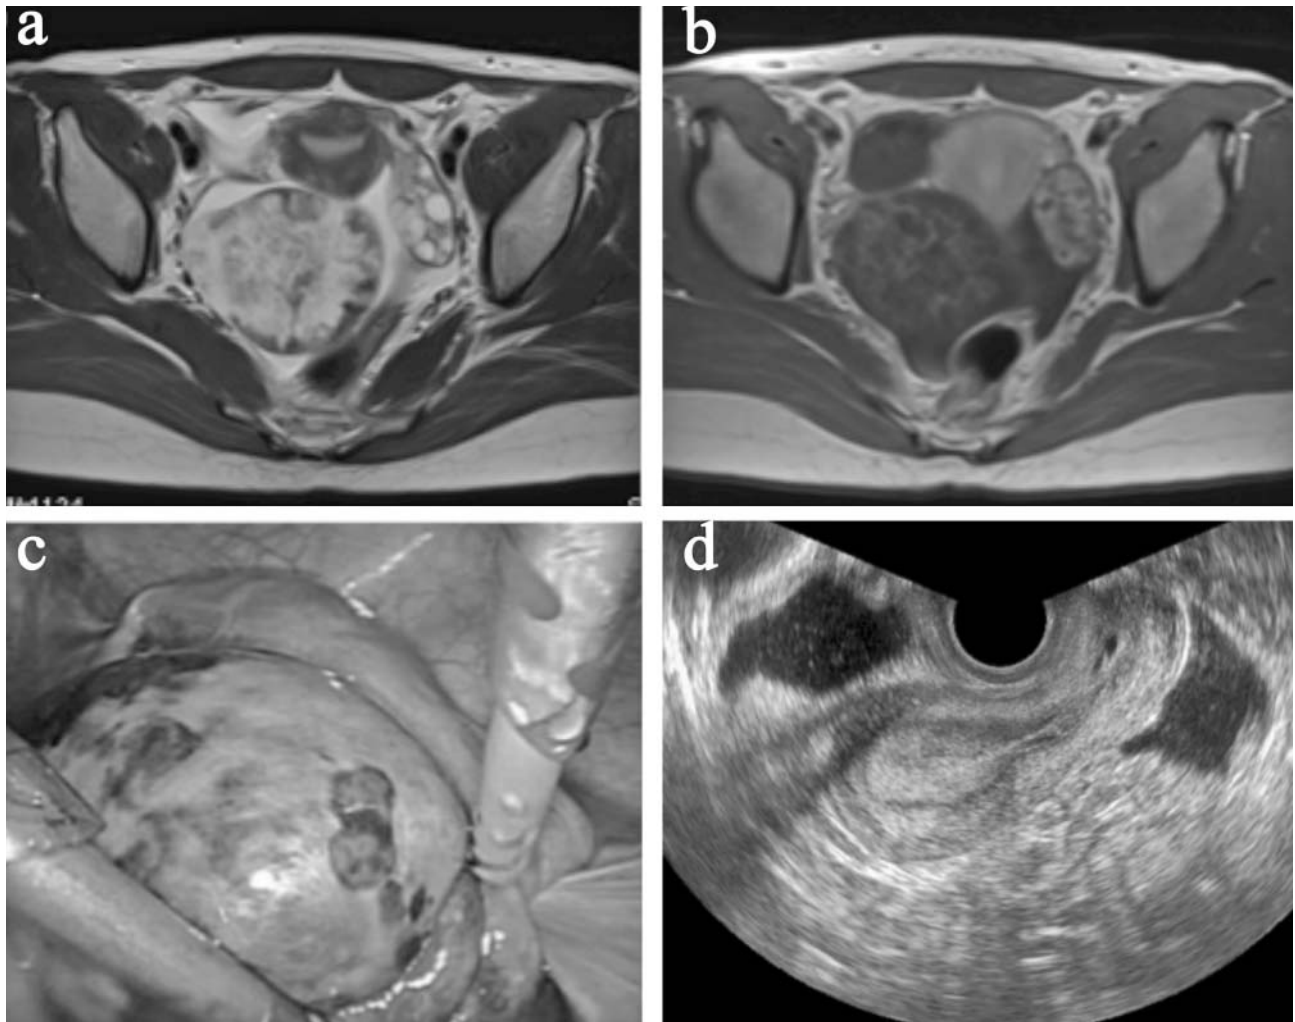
A) Unenhanced axial T2-weighted image clearly showing multiple small peripheral cysts, central stroma, and increased volume of the right ovary. B) Contrast-enhanced axial T1 image showing contrast enhancement of the left ovary and does not show hyperintense appearance of the right ovary. C) Laparoscopic approach showing a purplish-black right ovary that had undergone a 540° torsion around the utero-ovarian ligament. D) Ultrasonography image showing the endometrium in the luteal phase.
